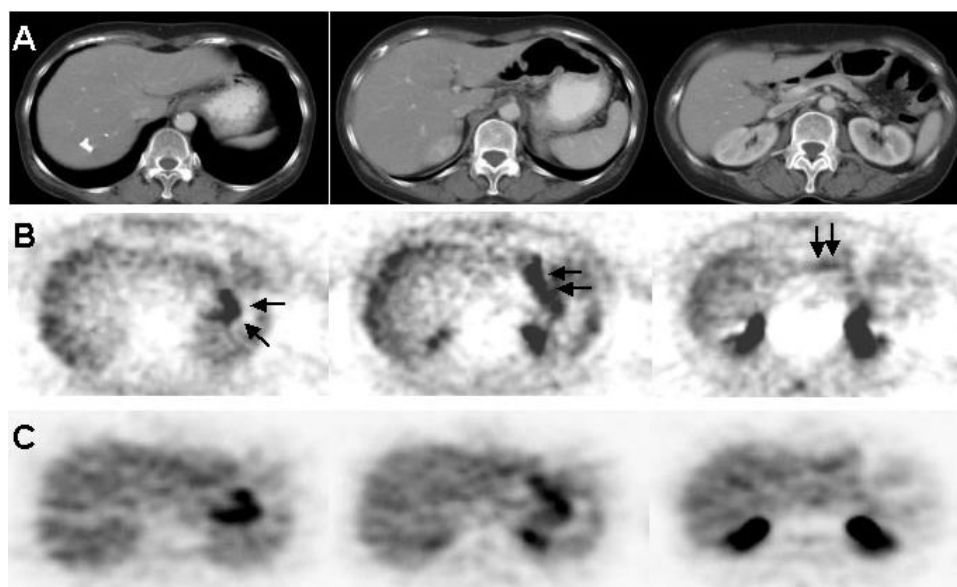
A sixty-two-year-old female with esophageal cancer (patient No. 2). (A) Contrast-enhanced CT images of the stomach. (B) FDG PET axial images without attenuation correction. The arrows indicate areas of FDG uptake in the U-, M-, and L-areas of the stomach, respectively. The FDG uptake scores obtained by visual grading were 3 in the U-area, 3 in the M-area, and 1 in the L-area. (C) FDG PET axial images with attenuation correction of the U-, M-, and L-areas. The SUVs in the three areas were 3.30, 3.14, and 1.78, respectively.
